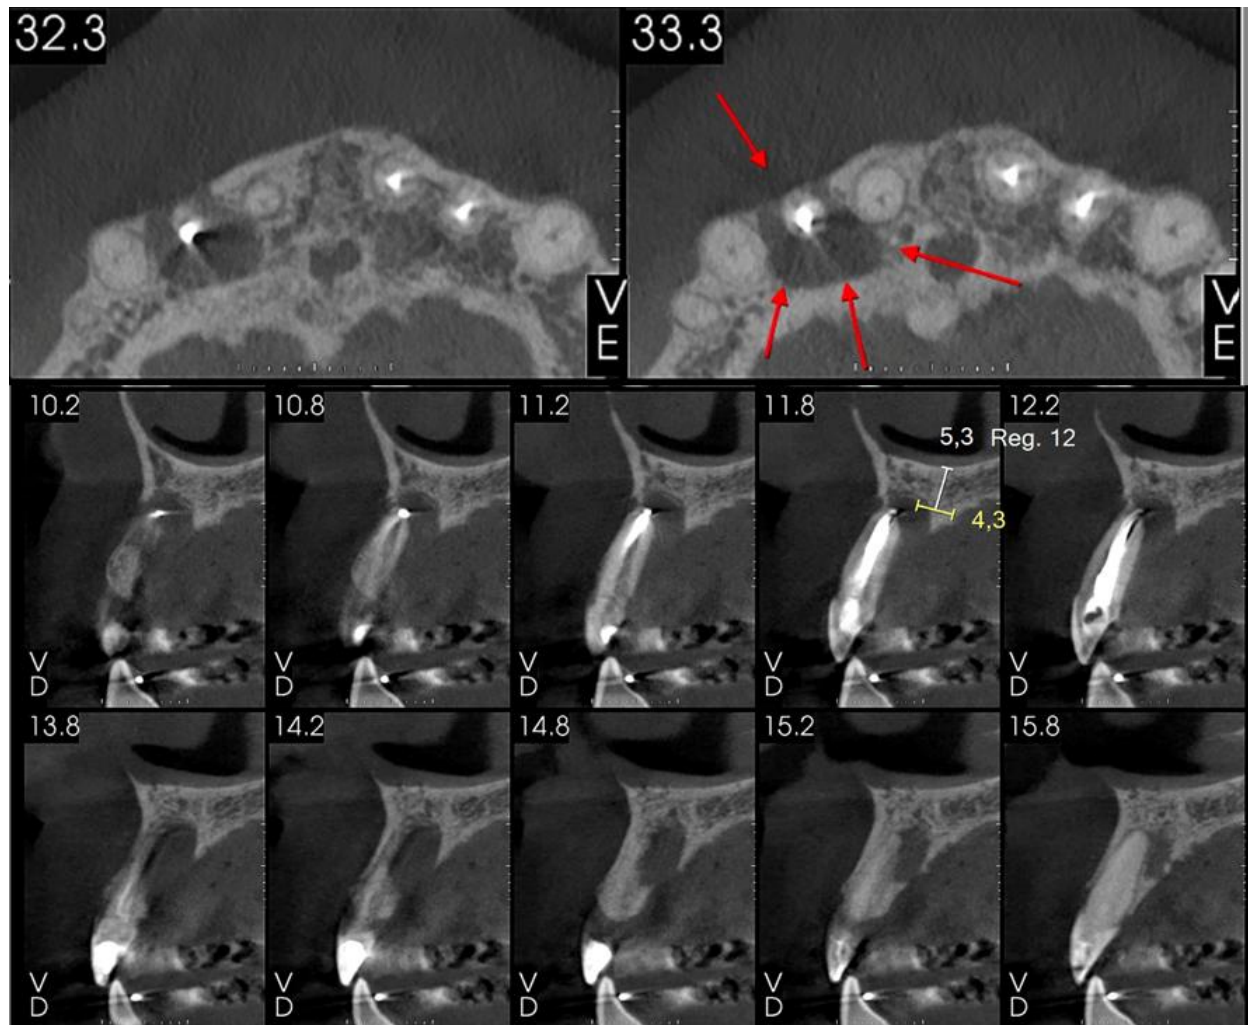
CBCT – Bone and external tooth resorption of tooth #12.
